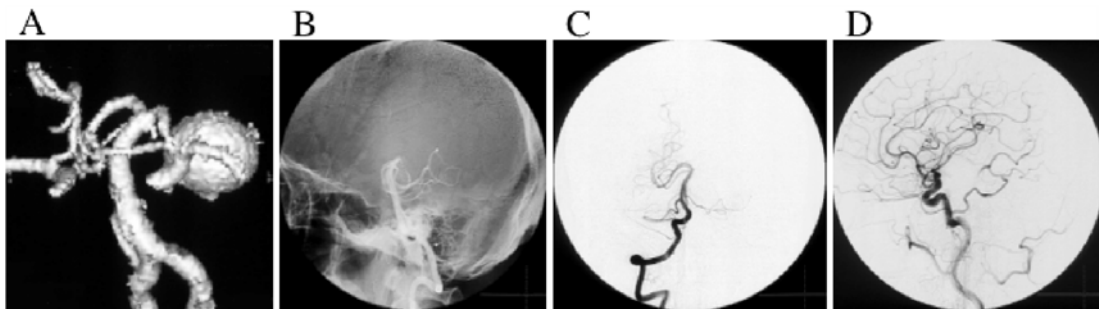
(A) 3D CT angiogram shows a high positioned large left PCA (P2) aneurysm. (B) Lateral view of angiogram demonstrates that the aneurysm was 2 cm above the posterior clinoid process. (C) Angiogram obtained after surgical trapping demonstrates complete obliteration of aneurysm. (D) The post-operative left carotid angiogram demonstrates that the distal left PCA was perfused via STA-PCA anastomosis
